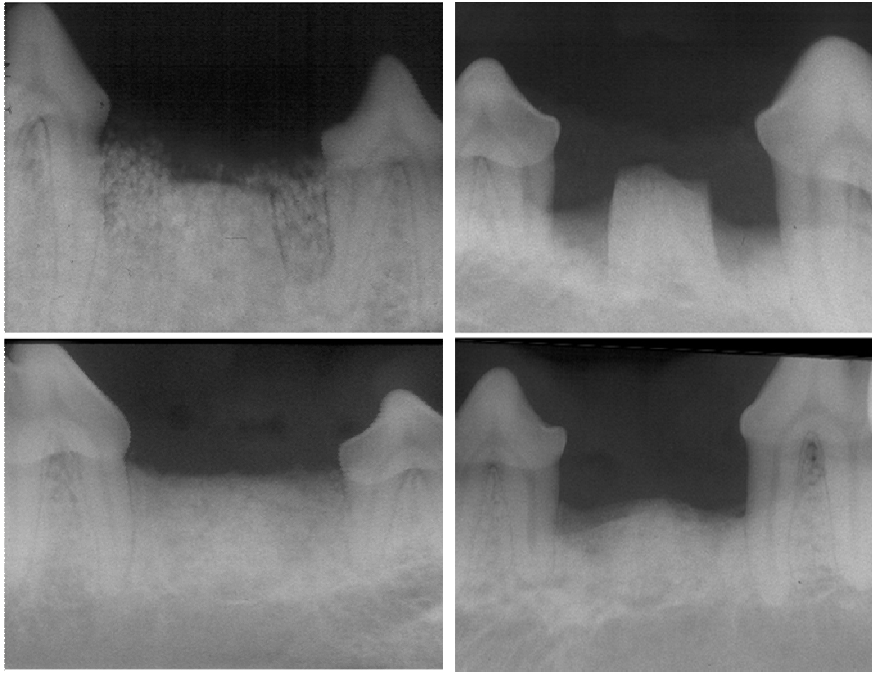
Radiographs of sites
